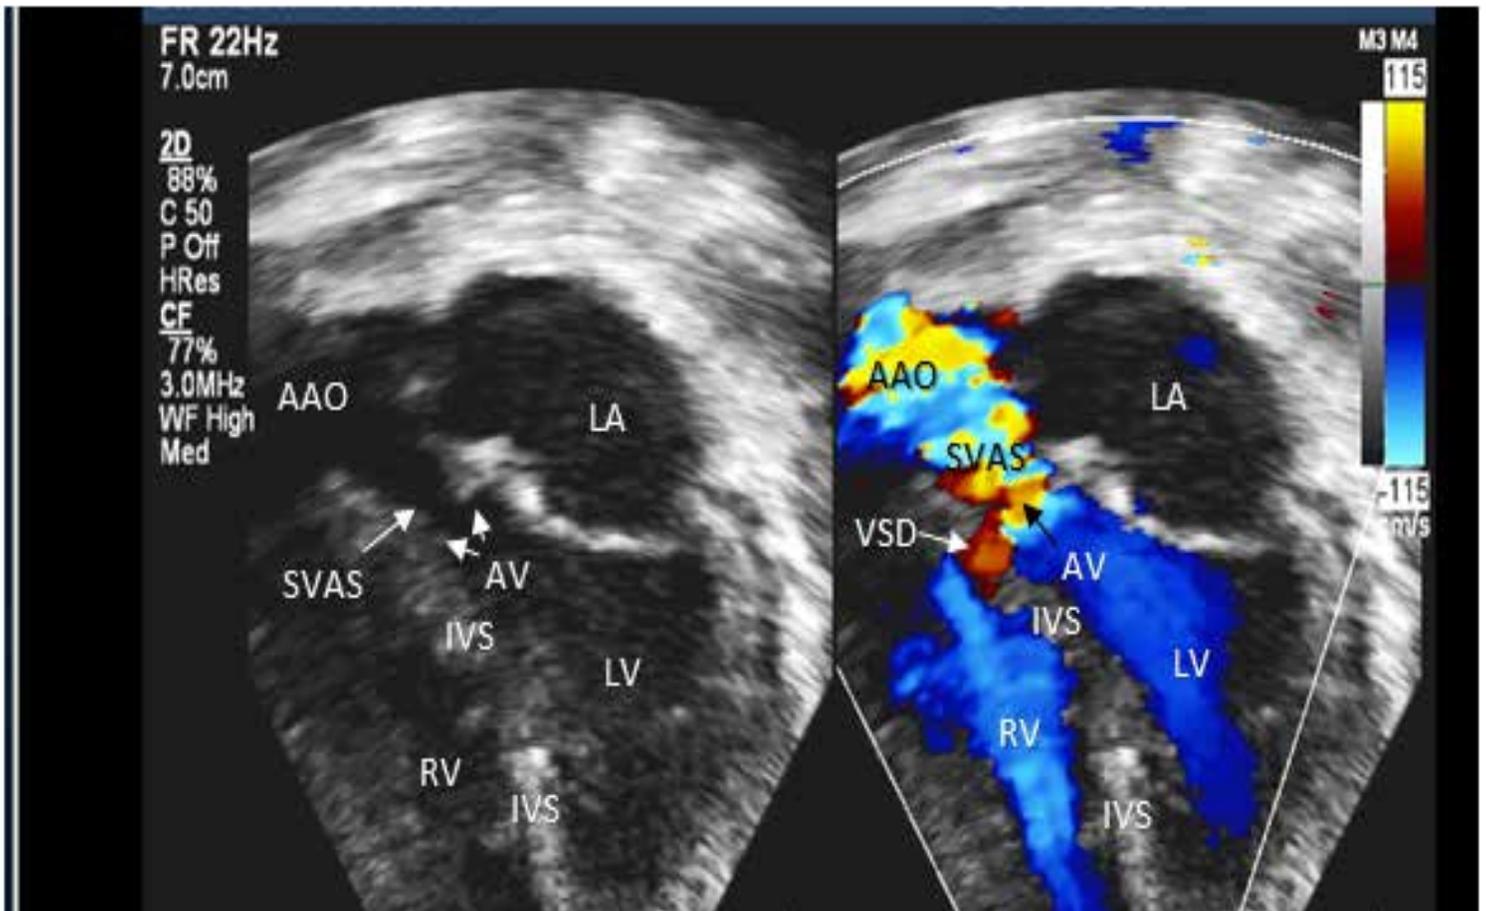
A 2D echo with color Doppler depicting Supravalvular aortic stenosis (SVAS) and ventricular septal defect (VSD) in apical 3-chamber view. AV; Aortic valve, AAO; Ascending Aorta, IVS; interventricular septum, RV; right ventricle, LA; left atrium, LV; left ventricle.
